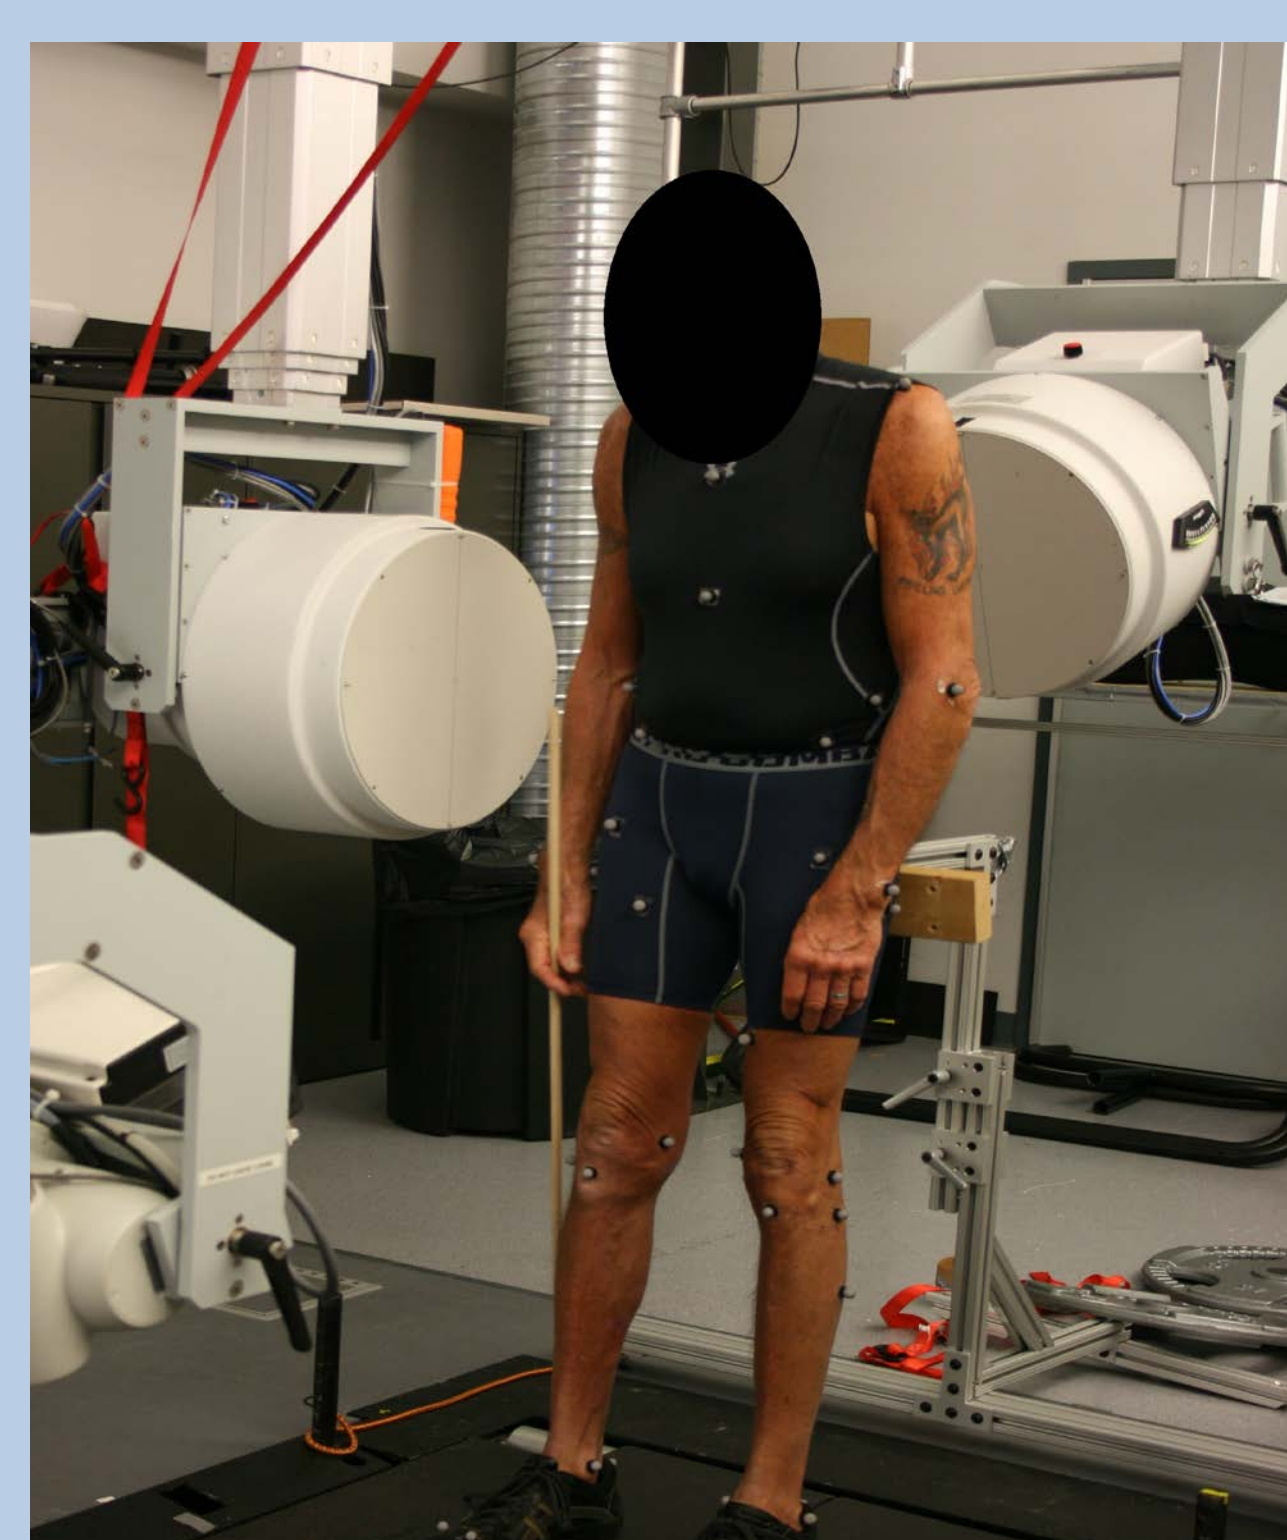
Example of a participant standing within the biplane x-ray system.
